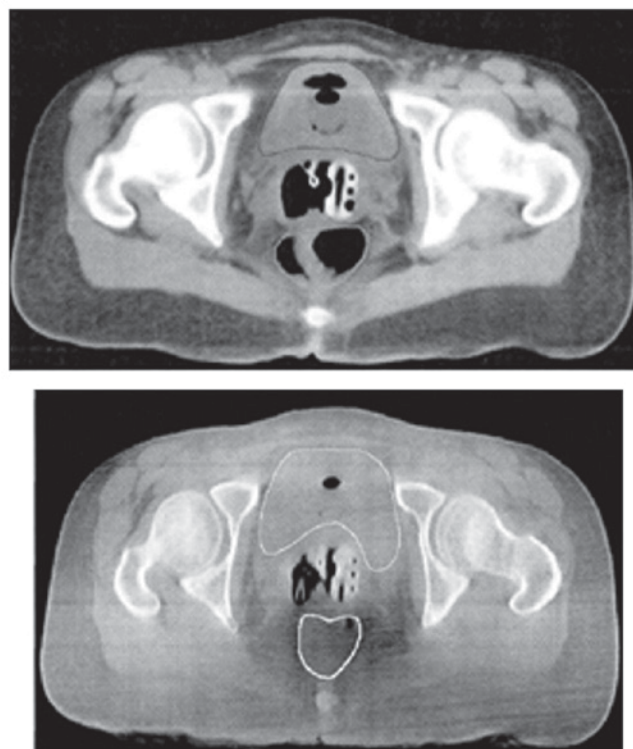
Fusion of first and second CT-Sim scans.
